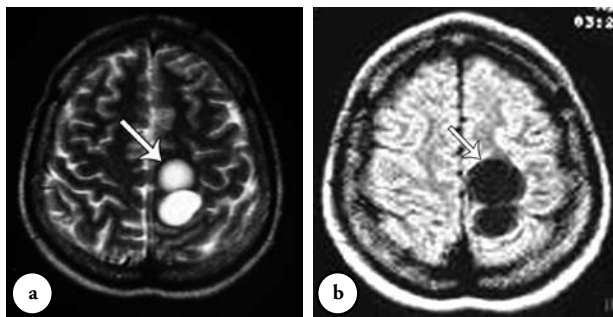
MRI showing a) axial T2 and b) FLAIR weighted sequences of the brain show that the cyst is well defined with signal intensity similar to that of CSF. Thick cystic capsule could also be noted.
